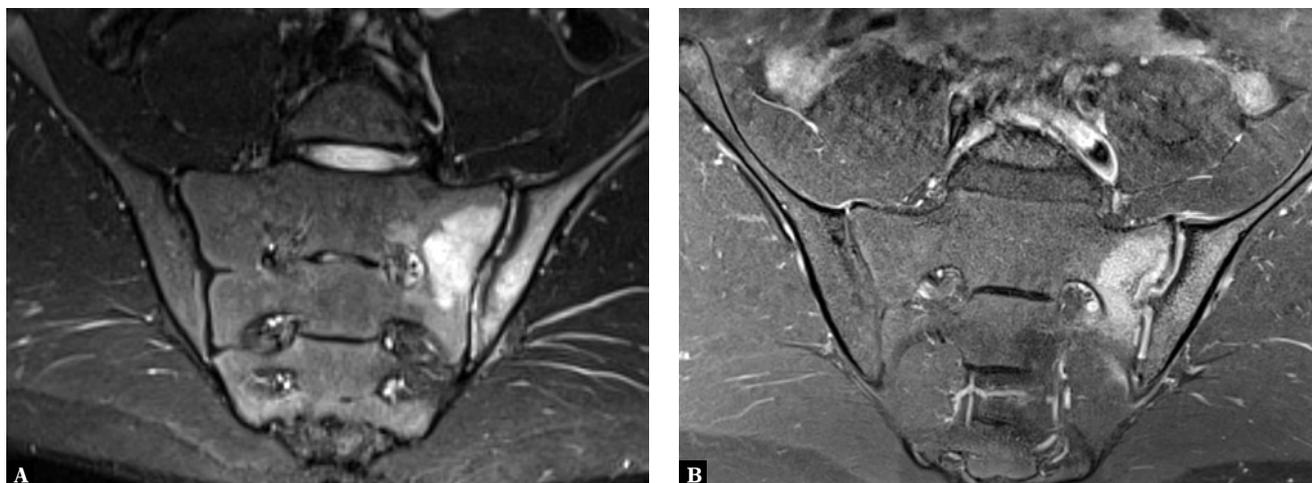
MRI of the sacroiliac joints in a 12-year-old boy with suspected sacroiliitis. Coronal oblique planes. A. T2-weighted TIRM, B. T1-weighted FS CM (contrast medium): bilateral bone marrow edema, more marked in the left joint, thickened contrast-enhancing synovium
